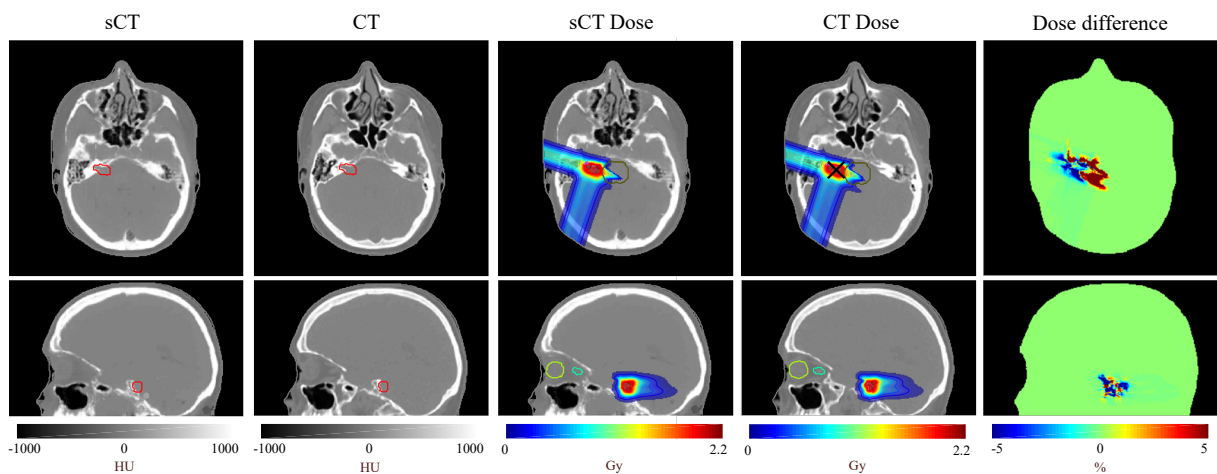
sCT, CT, dose calculated on the sCT and CT for the IMPT plan and dose difference between the two for a representative patient with a vestibular schwannoma. Sagittal and axial views at the tumour isocentre plane.
